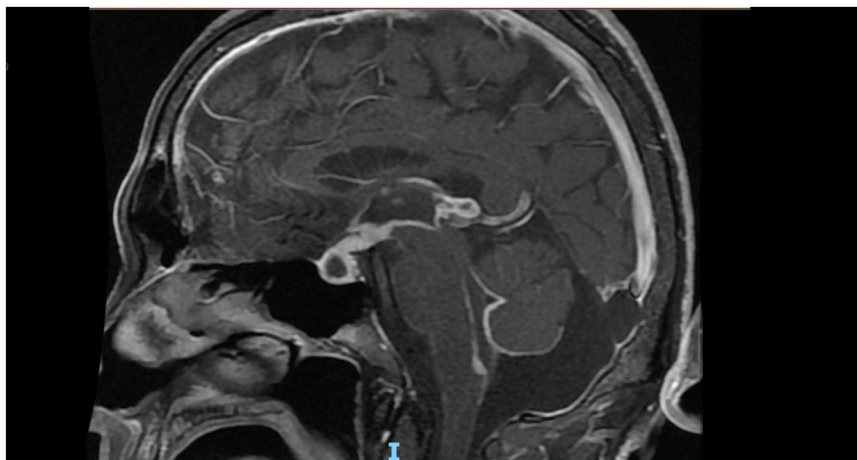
Pituitary gland magnetic resonance imaging (4 weeks later) showing an inflammatory process in the ependyma of the third and fourth ventricle and the hypothalamic region with sellar extension, due to irregular thickening and enhancement. Thickened infundibulum, with an intraglandular pituitary abscess, which measures 8 × 7 × 12 mm, with a 15% decrease in the volume of the collection compared with the previous study.
